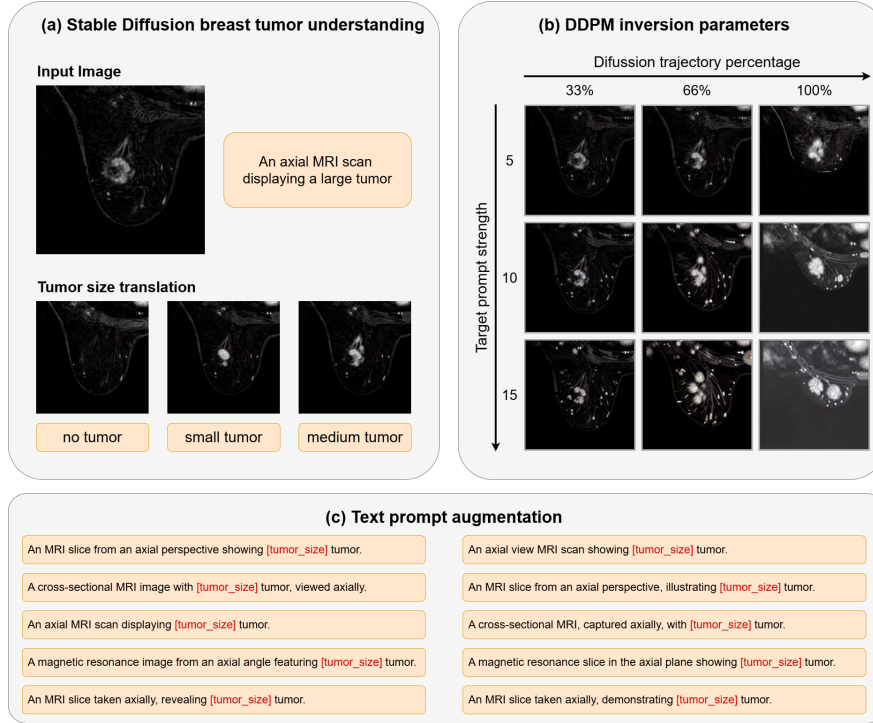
Overview of synthetic tumor generation and augmentation strategies. (a) Stable Diffusion ability to modify tumor presence in MRI images. (b) Effects of inversion trajectory and text prompt strength, showing increased sensitivity to long trajectories and loss of realism with strongly weighted prompts. (c) A diverse set of text prompts used to describe MRI images, enhancing variability in synthetic data generation.
